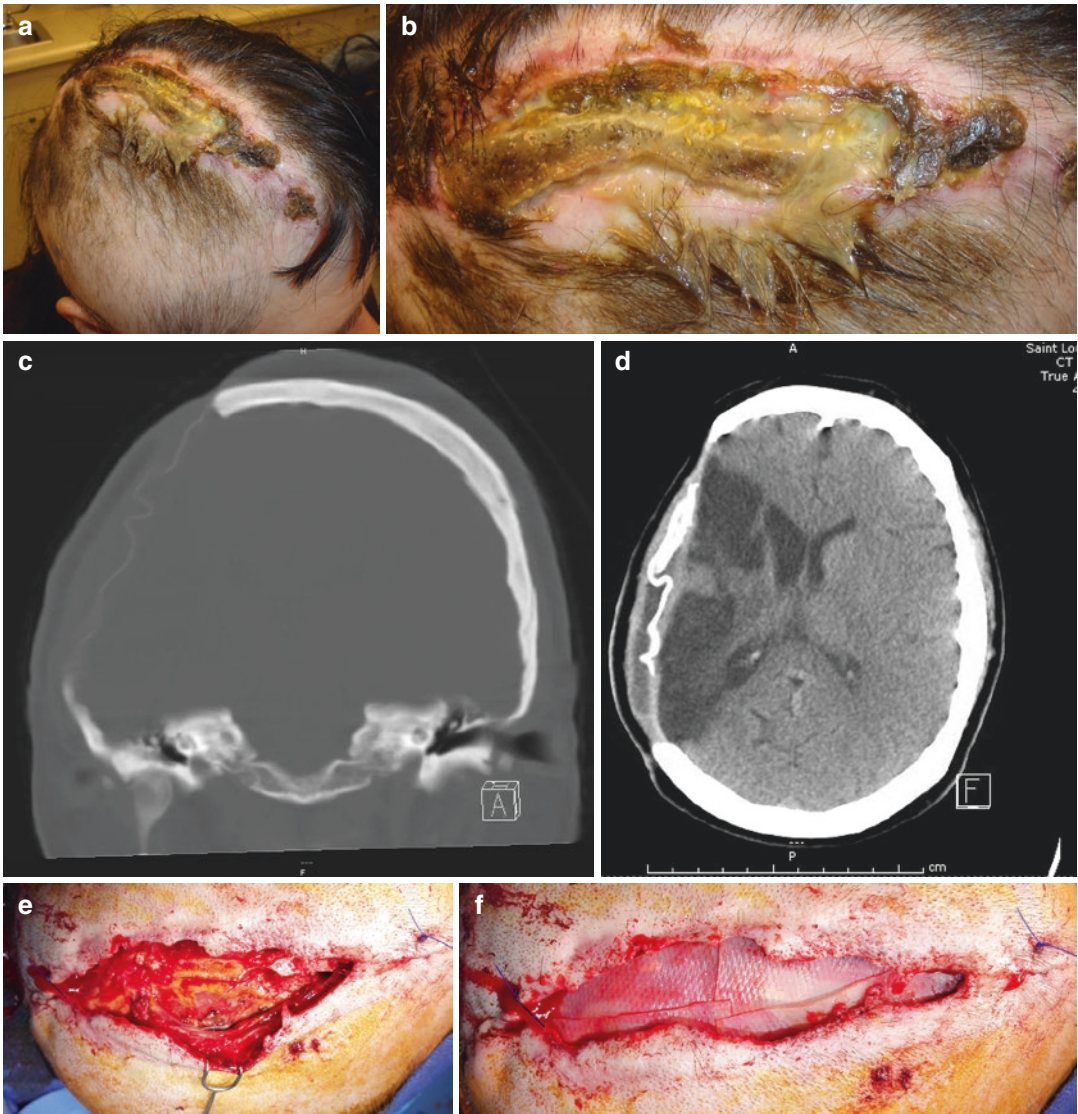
A 42-year-old female with a scalp wound following a decompressive craniotomy for a major right middle cerebral artery stroke. (a, b) Initial wound appearance showing exposed central cranial bone edge and poor wound care. (c, d) CT scan showing the calvarial bone defect and the Durepair® dura regeneration matrix (bright wavy line in d) used for dural closure/reinforcement. (e) Debrided wound with bone debrided back to bleeding and the dural edge present just above the hooks—no CSF leak
